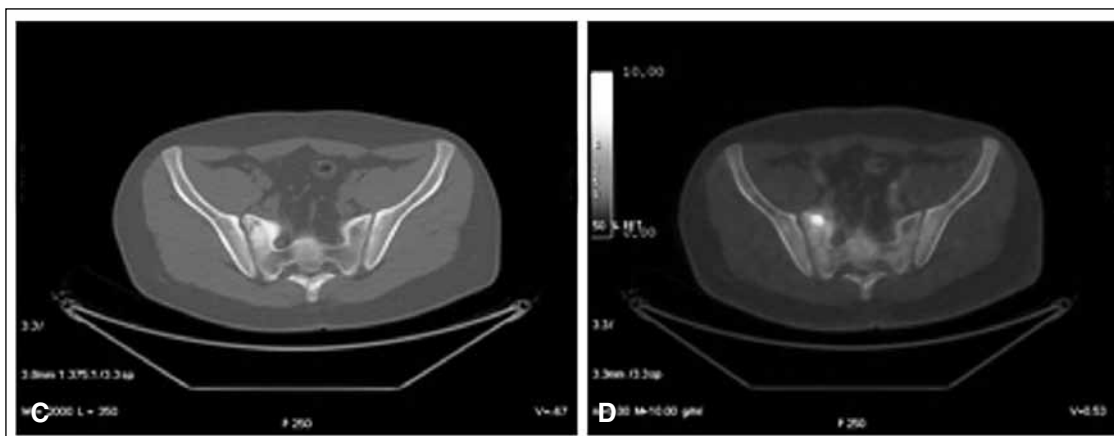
18F-FDG PET. A and B. Remarkable remodelling of left clavicle, which shows diffuse changes in density, with a sclerotic lesion that involves cortex and bone marrow, and lytic areas within. Hypermetabolism with maximal 7.1-SUV. Minimal component of adjacent soft tissues.
